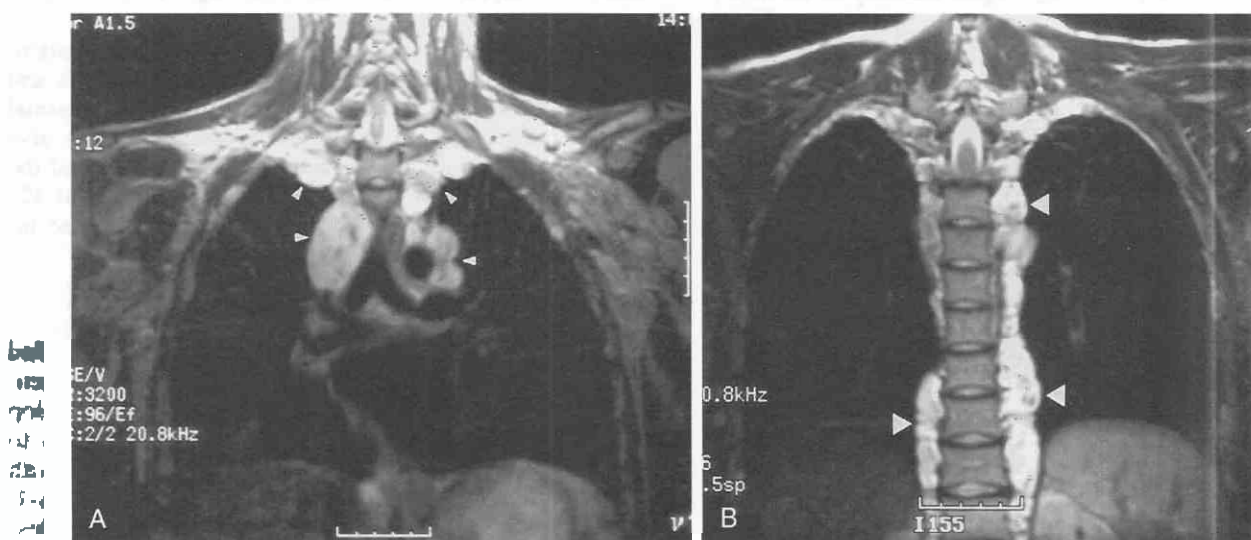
Plexiform neurofibromas in a woman with neurofibromatosis. Coronal T1-weighted (A) and T2-weighted (B) MR images show plexiform neurofibromas along the course of nerves in the superior, middle, and posterior mediastinum (arrowheads). Focal central hypointense regions within masses (target sign) are typical of neurofibromas. (From Rossi SE, Erasmus JJ, McAdams HP, Donnelly LF: Thoracic manifestations of neurofibromatosis-I. *AJR Am J Roentgenol* 173:1631–1638, 1999.)
